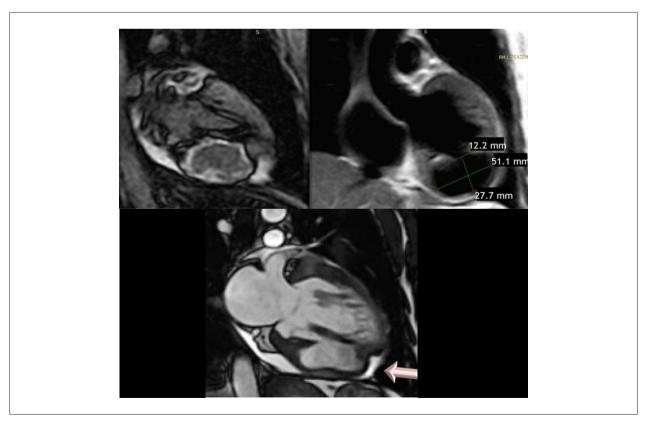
Cardiac Magnetic Resonance Imaging. In the upper-left image late enhancement is evidenced with gadolinium of ventricular aneurysm. Top right image with diameters of the aneurysmal sac. Bottom cine imaging with location of aneurysm in lower wall.
